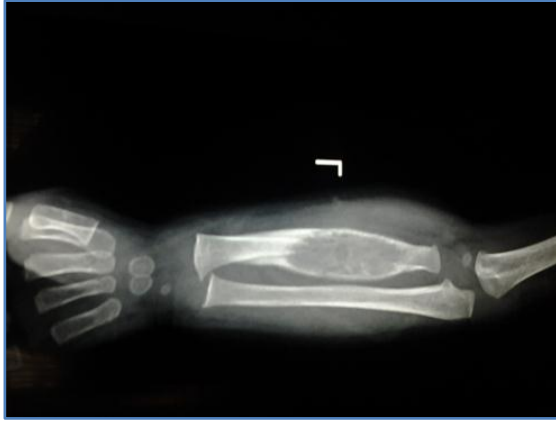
Plain radiograph of the left forearm revealing a lytic lesion with periosteal reaction in the radius
